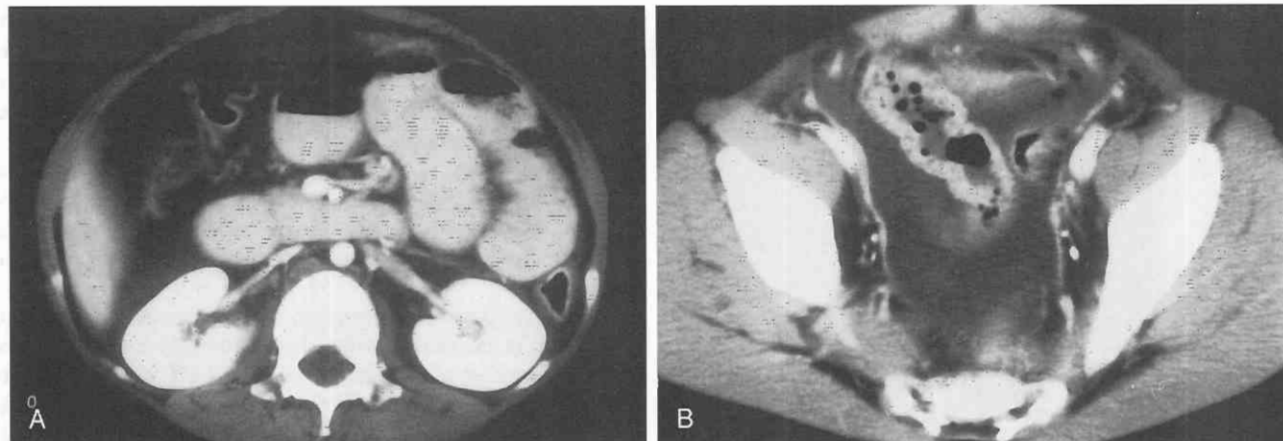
Jejunal rupture. *A*, CT scan through the upper abdomen of a patient injured in a motor vehicle crash shows free peritoneal fluid in Morison's pouch. *B*, CT scan through the pelvis in the same patient shows a large amount of peritoneal fluid. No solid viscus injury was identified. At surgery, a jejunal rupture was noted.
